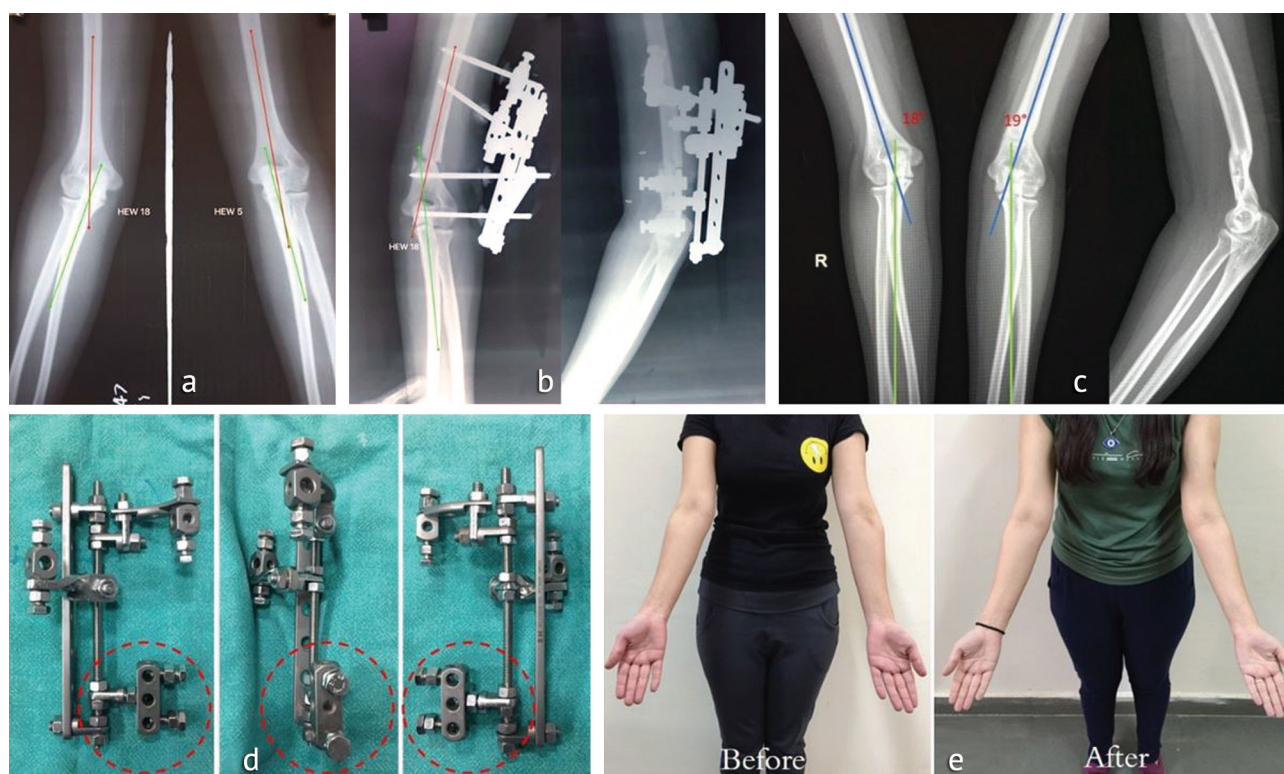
Case of a 17-year-old girl: (a) pre-operative radiographs of cubitus rectus; (b) post-operative radiographs following mini-Ilizarov correction; (c) final follow-up radiographs showing accurate correction, comparable to contralateral elbow; (d) mini-Ilizarov frame assembly, red circled portion represents the swivel-type Rancho cube for the distal fragment; (e) clinical images before and after correction
